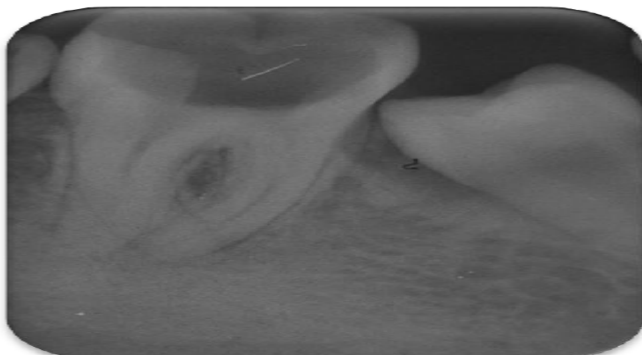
Initial radiography of the 46
